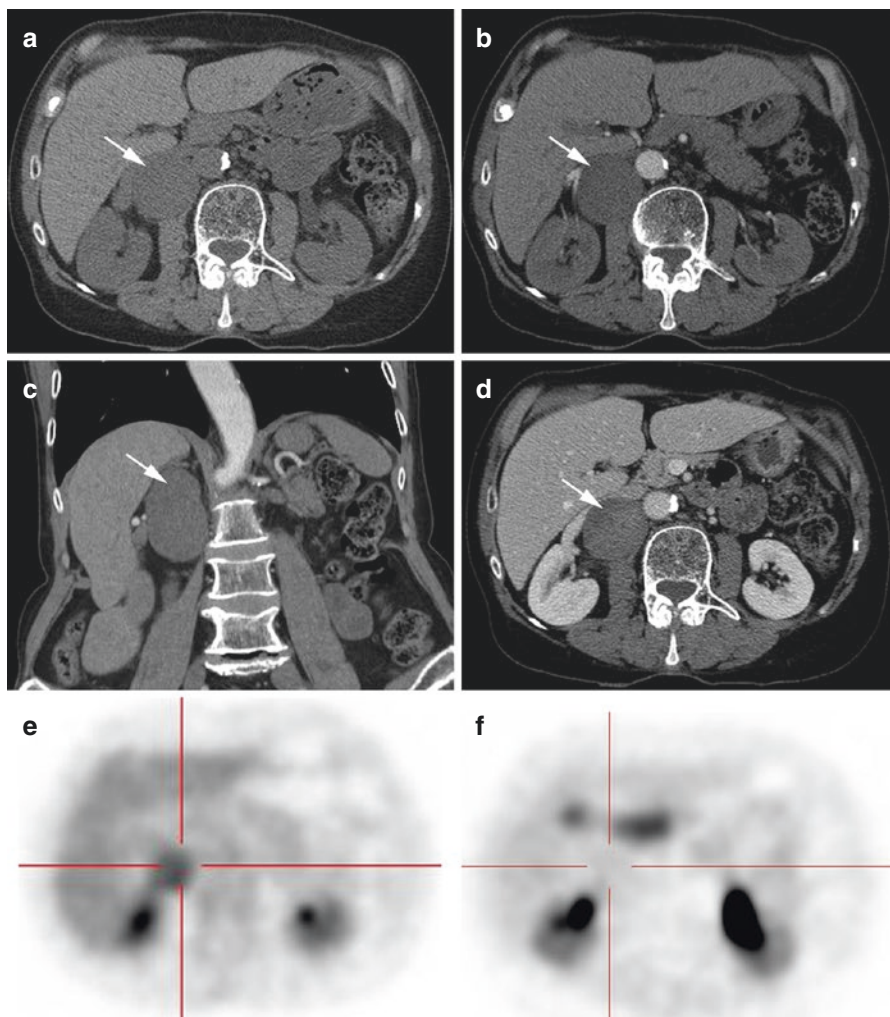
Retroperitoneal neurofibroma. CT scan showed a retroperitoneal para-aortic solitary mass with a moderate and progressive homogeneous contrast enhancement. ^{18}F -FDG PET showed a mildly increased ^{18}F -FDG uptake, and ^{18}F -FDOPA PET was negative. (a) Unenhanced CT, 28 HU; (b) arterial contrast-enhanced CT, 36 HU; (c) arterial contrast-enhanced CT (reconstruction); (d) portal-phase contrast-enhanced CT, 70 HU; (e) ^{18}F -FDG, moderate tumor uptake (SUV_{max} = 3.6); and (f) ^{18}F -FDOPA PET, absence of tumor uptake. Pathological analysis found a cellular neurofibroma with atypia (Ki-67 10–15%)
